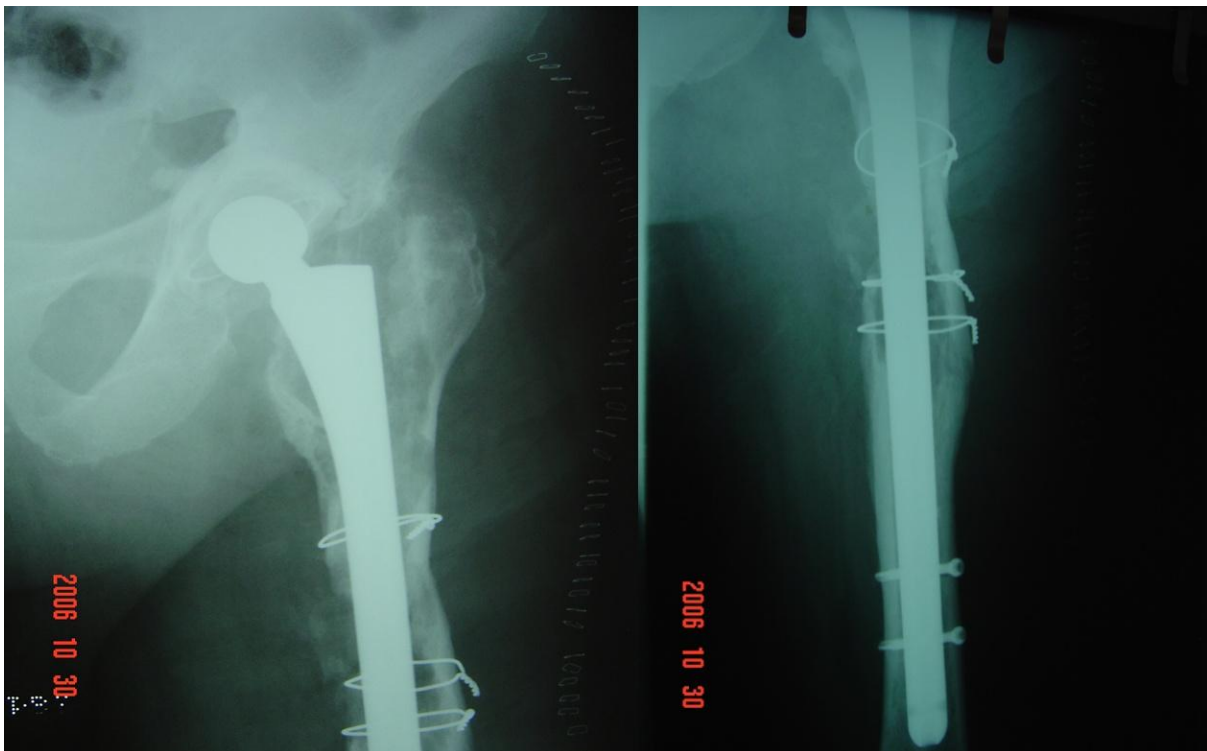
Post-operative AP radiographs of the left femur showing fixation of a Type B3 fracture with a long-stemmed distally locked implant
